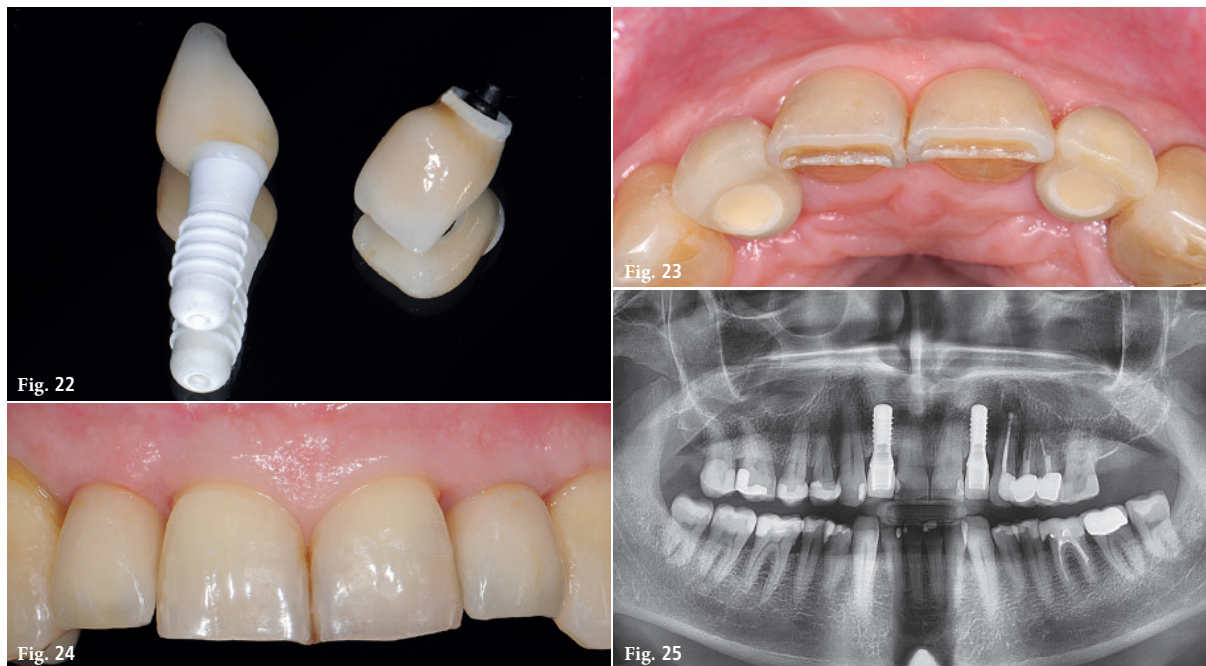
Directly overpressed, metal-free screw-retained crowns. – Fig. 23: Palatal closure of the screw channel. – Fig. 24: 1.5 years post-operation. – Fig. 25: Orthopantomogram (OPG) 1.5 years post-operation.
